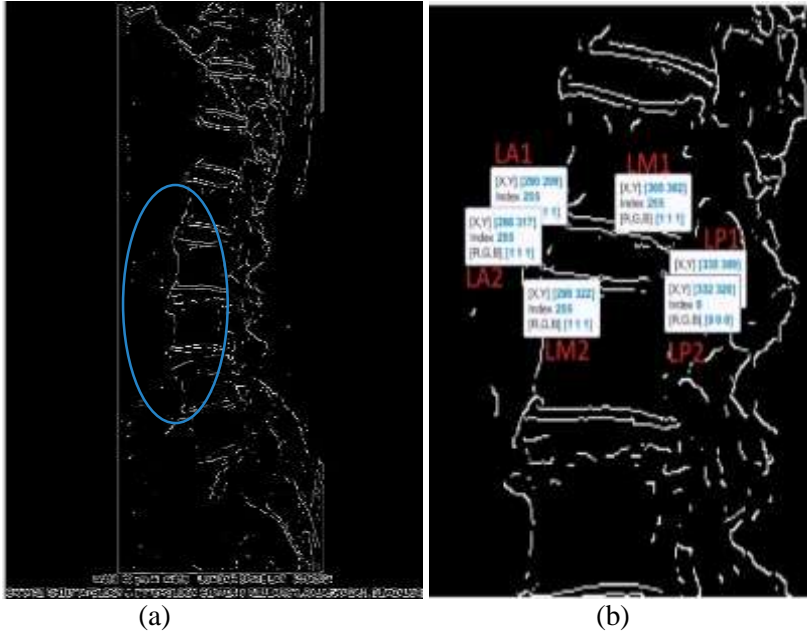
a) Edge detected x-ray image of an LBP subject; b) Pair points marked in LA, LM, LP regions
